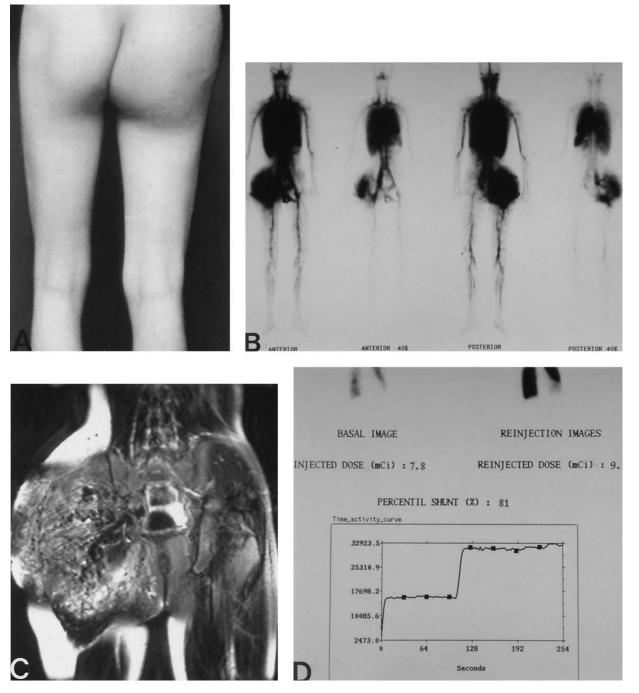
Isolated ethanol sclerotherapy of an AVM. A, Clinical appearance of the AVM lesion affecting the hip region with progressive symptoms. B, WBBPS finding of the extent of hemodynamically aggressive AVM lesion along the right hip; note the enormous size of right iliac artery equivalent to the size of abdominal aorta. C, MRI finding of the AVM lesion, confirmed as infiltrating type of the extratruncular form, affecting entire right hip soft tissue and muscles, and so on. D, TLPS finding of the AV shunting status of the lesion (pretreatment baseline study).
